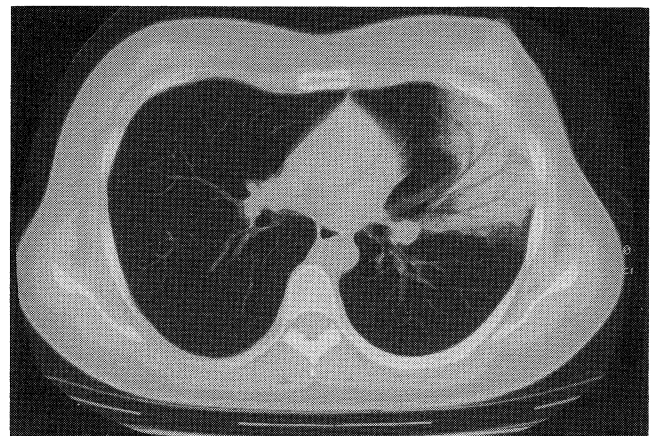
Chest computed tomographic scan of case 2 demonstrates an infiltrative shadow in the left middle lung field.
